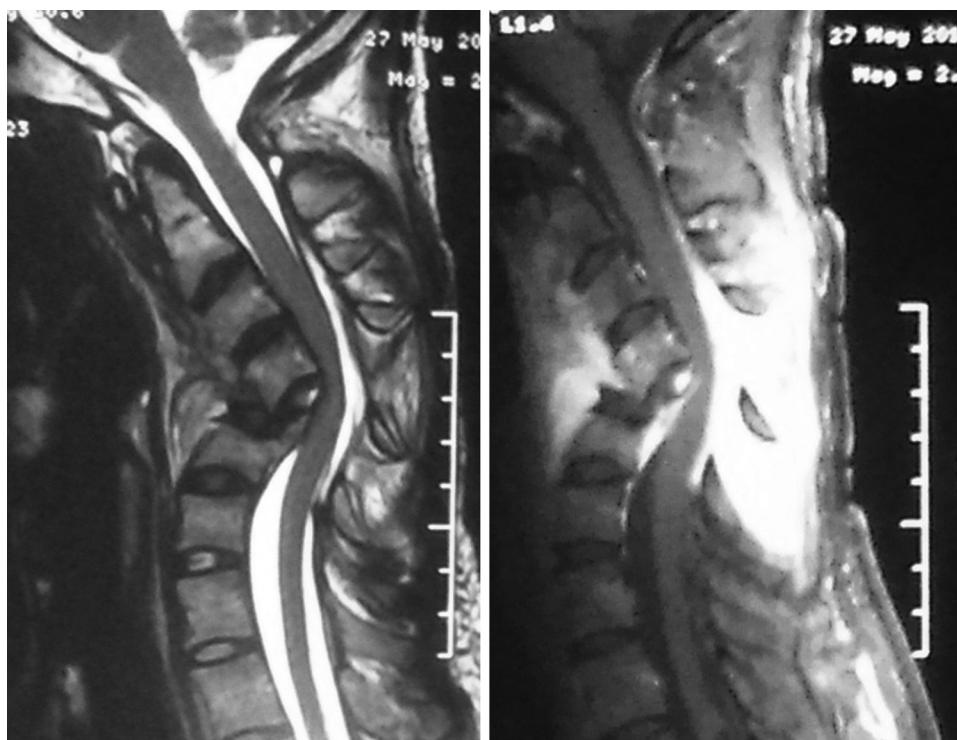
(Left) Sagittal T2-weighted magnetic resonance imaging (MRI) revealed a spinal cord angulations with mild compression associated with thinness of paravertebral soft tissues. (Right) T1-weighted MRI with injection of gadolinium showed enhancement of paravertebral soft tissues and discale involvement with epidural abscess.
